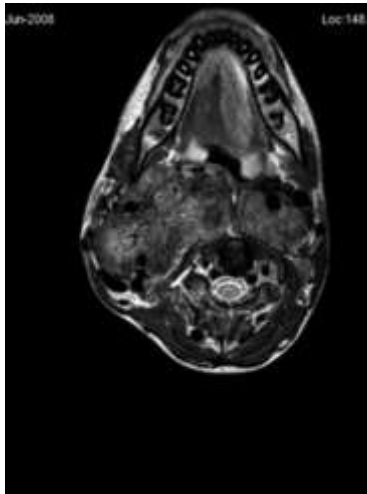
Pre-treatment neck MRI showing splaying of ICA, ECA on the right side by CBP where as the vessels are pushed anteriorly on the left side by vagal paraganglioma.
